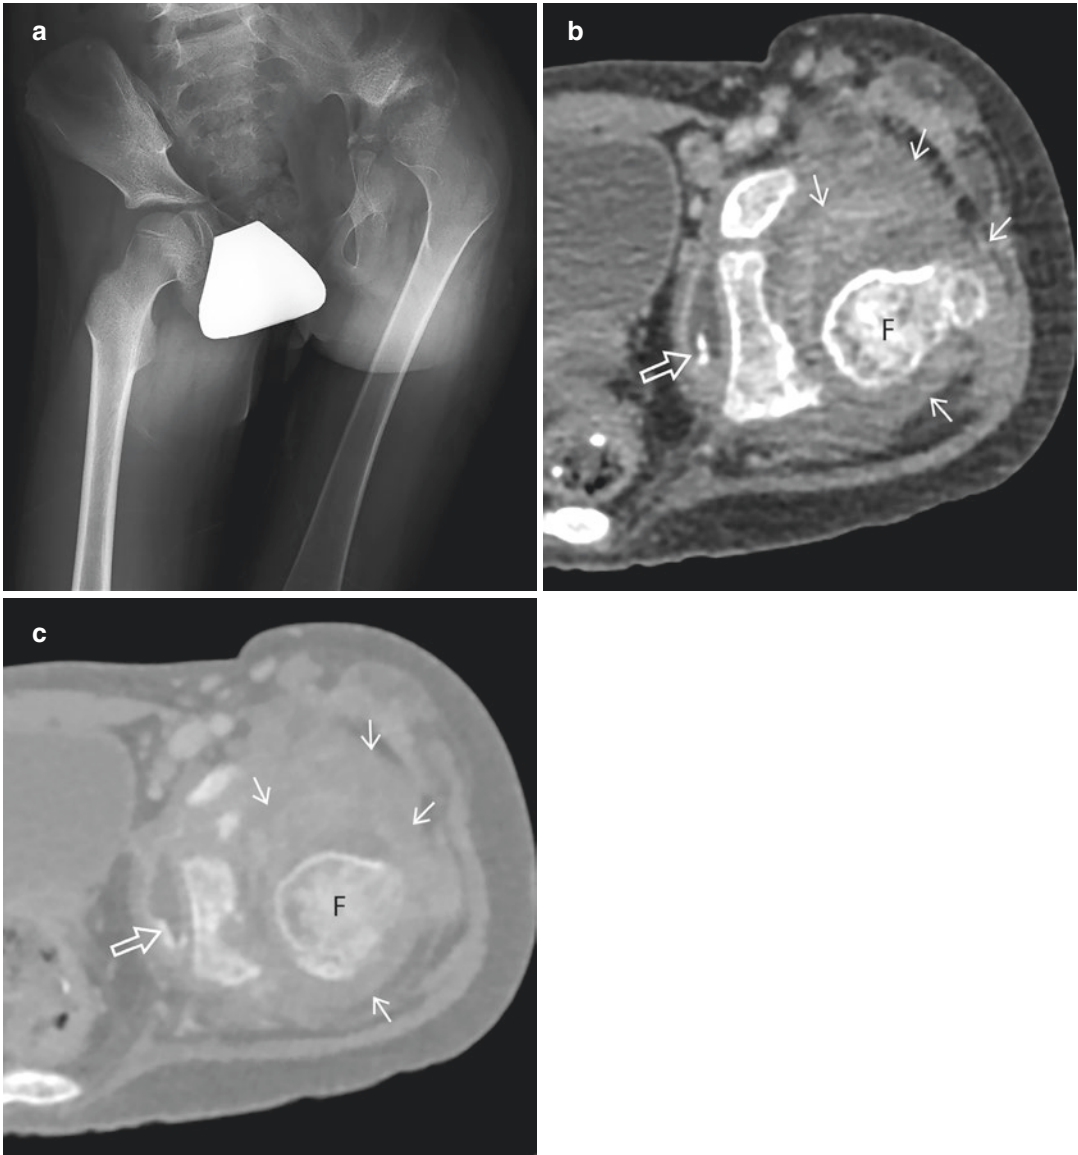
Tuberculous arthritis with subluxation in a 6-year-old girl who had left hip pain and limb length discrepancy. (a) Frontal radiograph shows destruction of the left hip joint and shortening of the left limb. Axial CT
